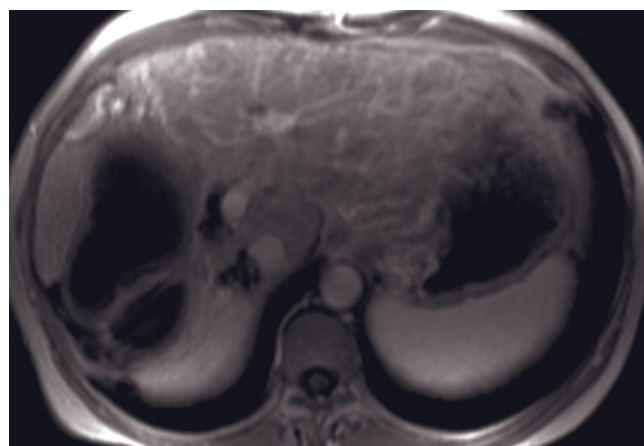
Recurrent HCC. SGE (a), 45-s postgadolinium SGE (b), and 90-s fat-suppressed postgadolinium SGE (c) images. This patient had previously undergone a left hepatic lobe resection for HCC. There are multiple lesions throughout the right lobe, all of which appear low signal on T1-weighted images (a) and exhibit lesional enhancement after gadolinium (b, c), consistent with recurrent disease. Note the large volume of tumor along the resection margin consistent with incomplete excision.
